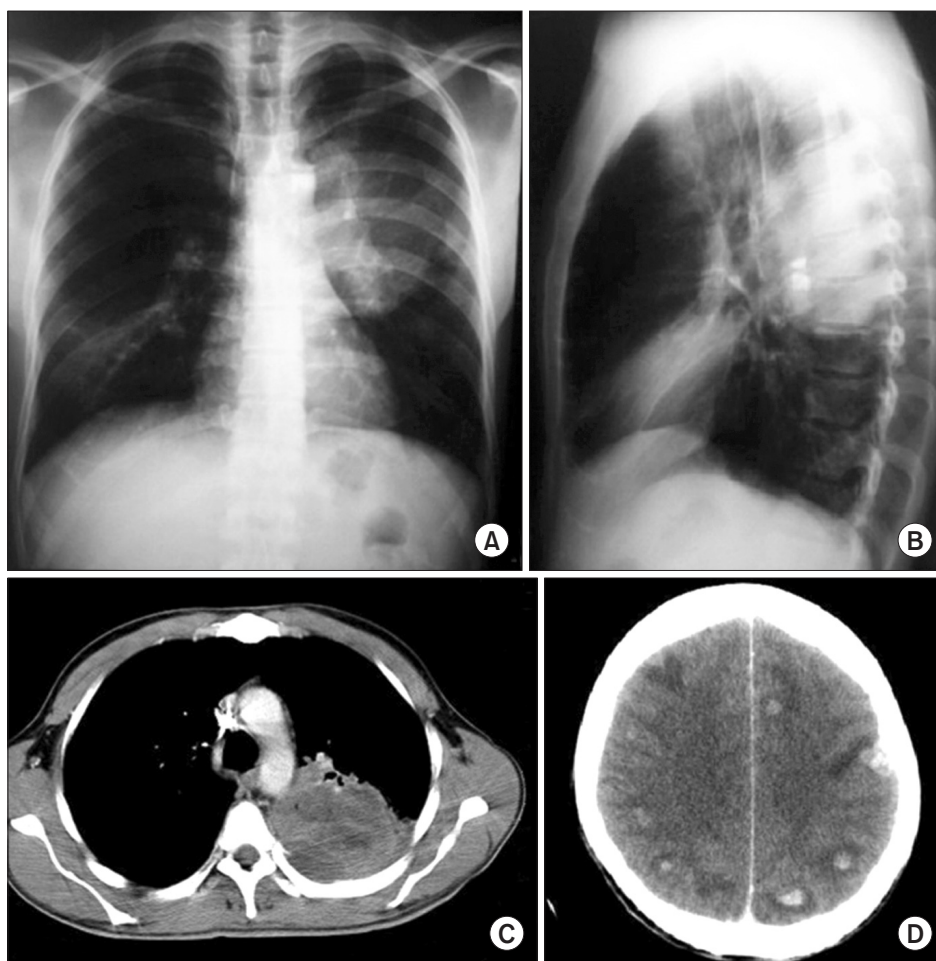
Chest radiographs and chest and skull computed tomography (CT) scans of a 36-year-old male, smoker, with progressive dyspnea, weight loss, and productive cough. (A, B) Chest radiograph with opacity in the inferior lobe and in the left superior lobe. (C) Chest CT scan with voluminous lesion in the left lung. (D) Skull CT scan with nodular lesions in the brain hemispheres. Fibrobronchoscopy with biopsy of polypoid lesion in the bronchus of the left inferior lobe identified *Cryptococcus* sp. cultured with *C. gatti* growth.
